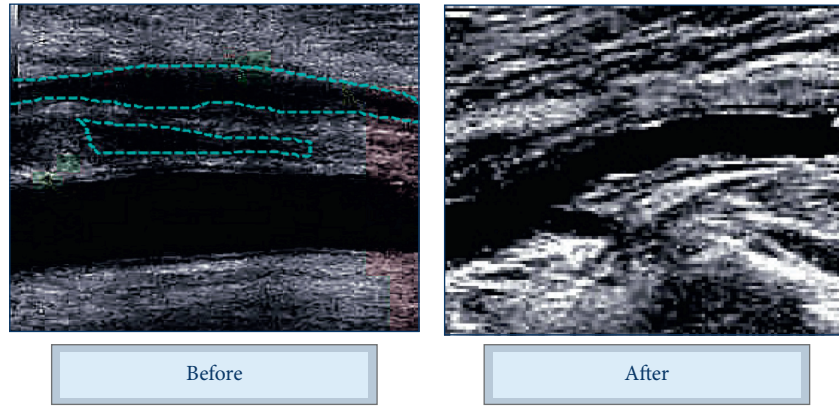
Comparison of ultrasound before and after treatment in the acupoint application group.
